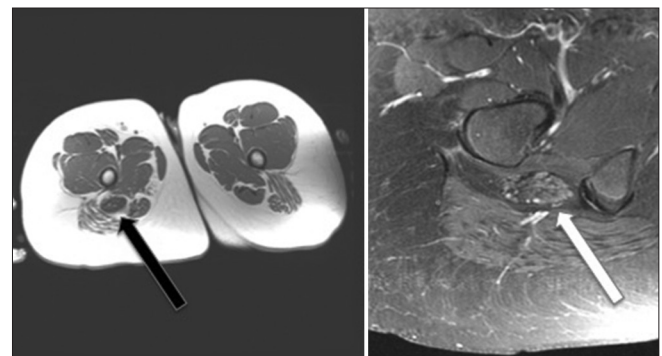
Precontrast (left) and postcontrast (right) axial T1-weighted magnetic resonance images of the lower extremity demonstrate the presence of a well-circumscribed, mildly heterogeneously enhancing mass in the location of the right sciatic nerve (arrows)
